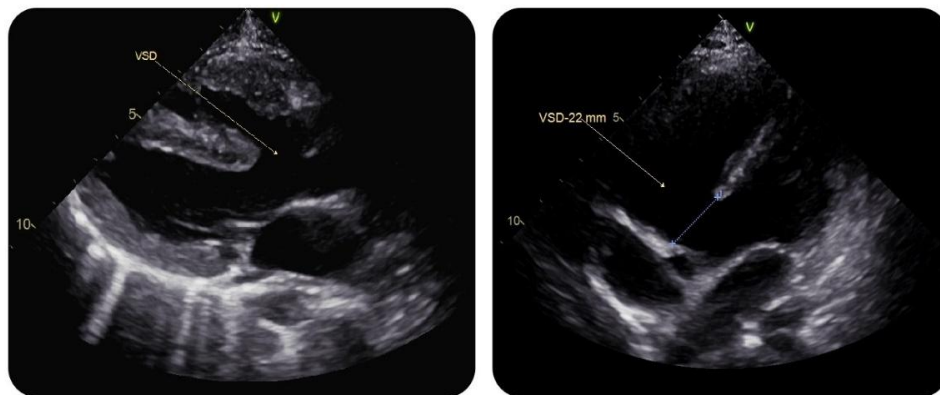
Echo - parasternal long axis view and apical 4 chamber view showing large VSD
